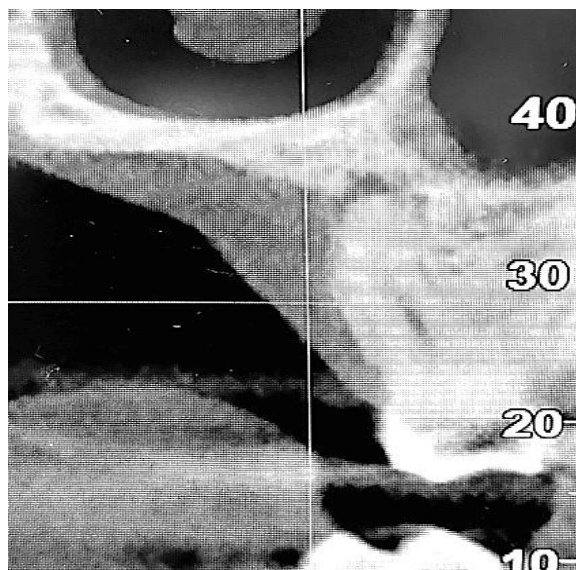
Palatal root with periapical lesion observed in the coronal plane.
